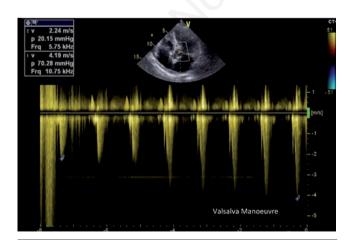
Continuous-wave doppler demonstrating a LVOT peak gradient decreasing to 20 mmHg, with a dynamic increase to 70 mmHg during Valsalva maneuver after LV apical ballooning resolution.
